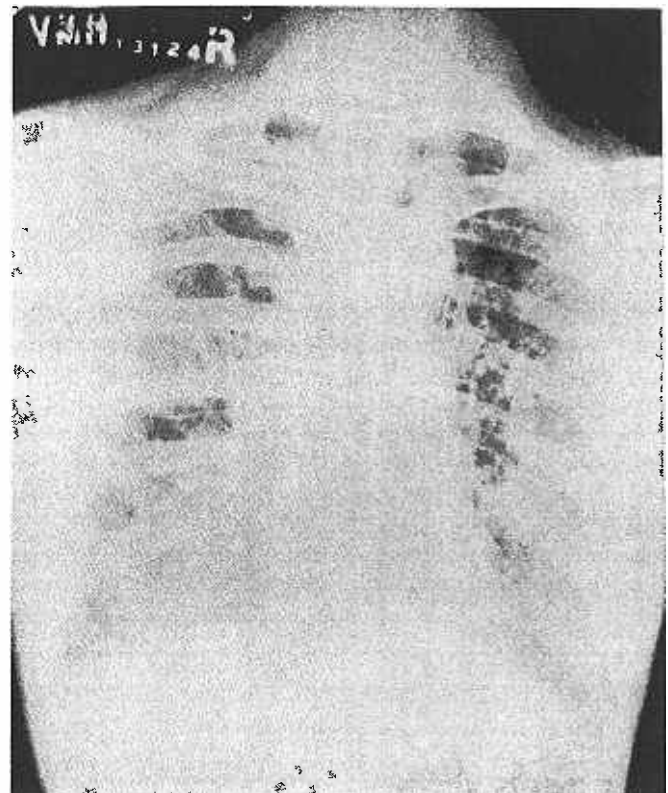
Chest radiograph taken on 26th October 1970. There is some slight clearing of the diffuse opacities with cystic appearances over both apical and basal regions.
